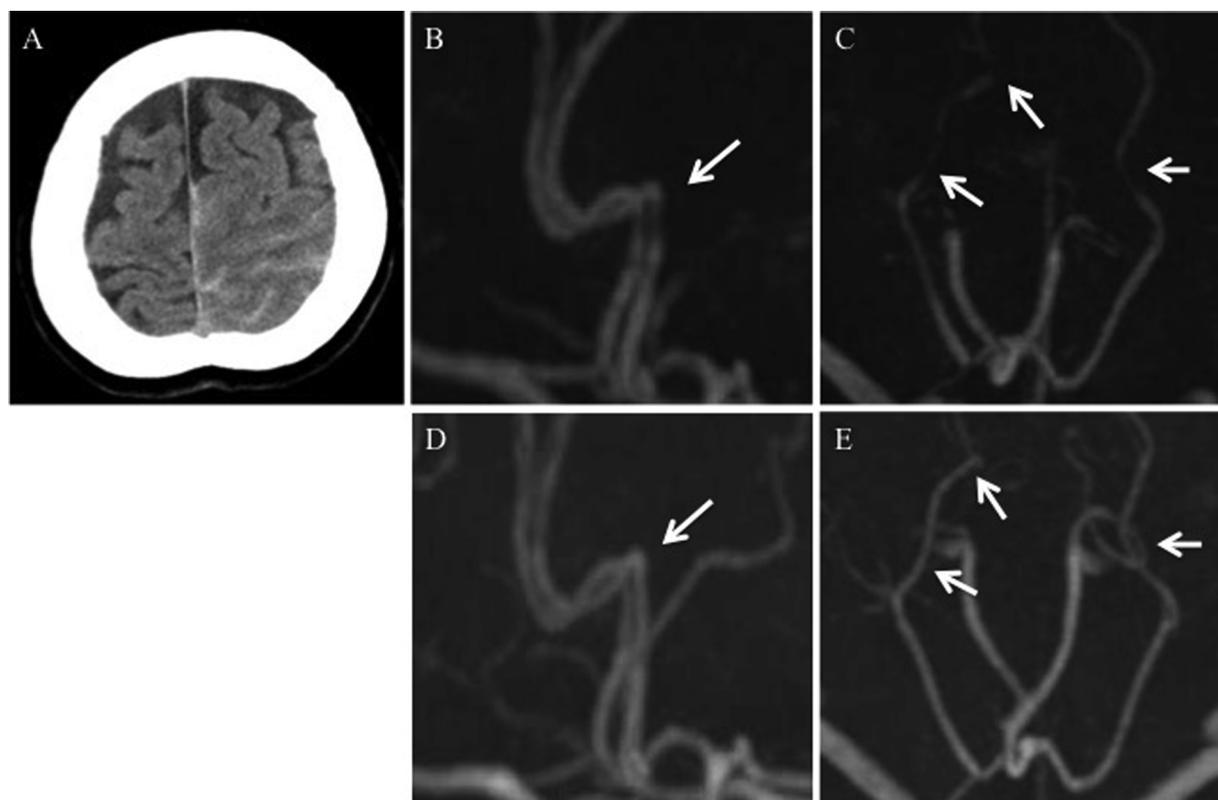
Brain imaging findings. (A) Computed tomography showing cortical subarachnoid hemorrhage in cerebral falx and left parietal region. (B) Magnetic resonance angiography (MRA) showing no cerebral aneurysm and vascular constriction at the left anterior cerebral artery (arrow). (C) MRA showing multiple vascular constrictions at the bilateral posterior cerebral artery (arrows). (D and E) MRA 1 month after onset showing significant improvement of vasoconstrictions (arrows).
